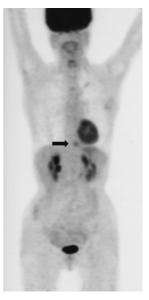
Fluorodeoxyglucose positron emission tomography (FDG-PET) showing high accumulation of tracer in the esophagogastric junction.
